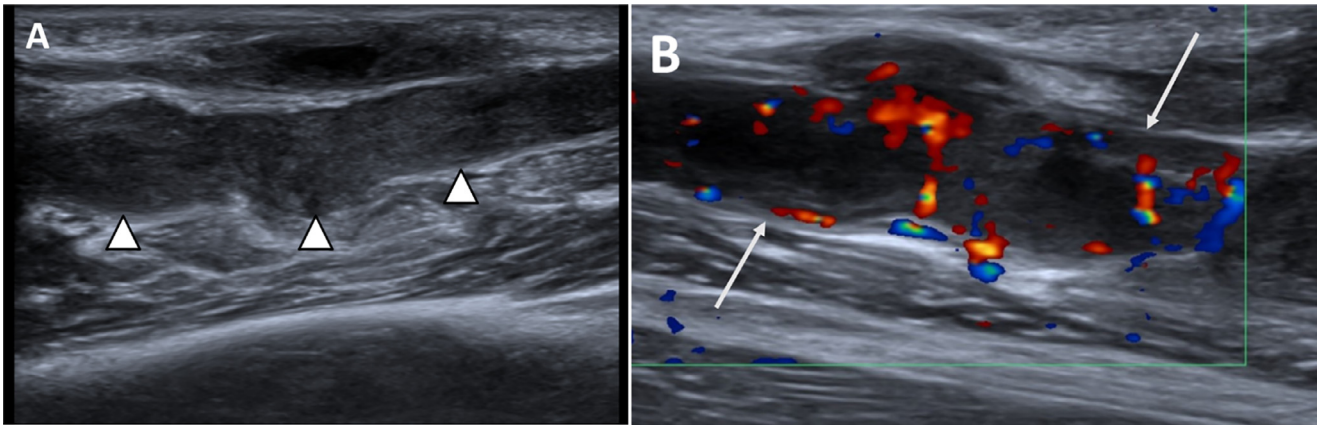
Grey-scale (A) and color Doppler ultrasound (B) images of the ulnar nerve in a 33-year-old man with ulnar nerve palsy. (A) Grey-scale ultrasound image shows marked nodular thickening of the ulnar nerve with nodular hypoechoic areas (arrowheads). (B) Color Doppler image of the ulnar nerve shows marked increased vascularity (long white arrows).
